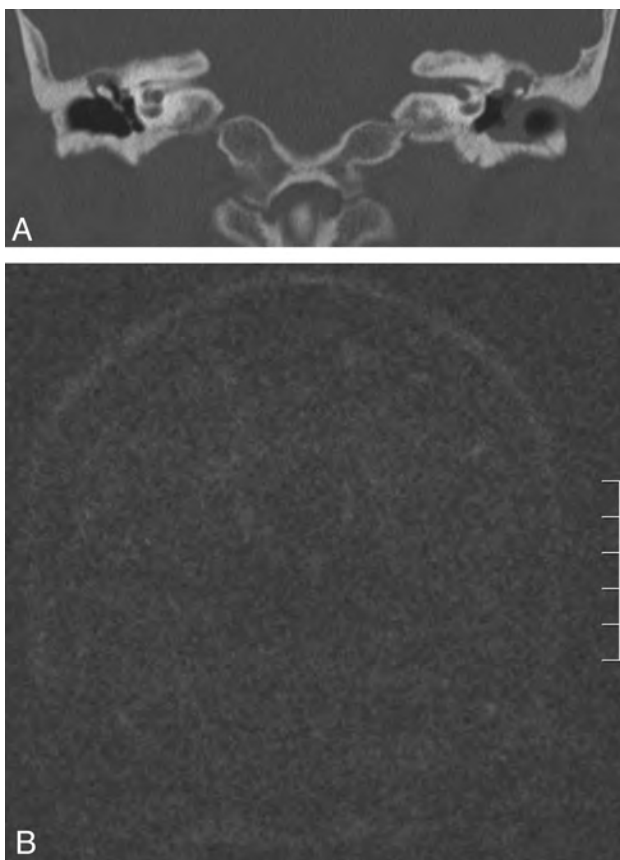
Case 13. A 58-year-old woman with bilateral chronic ear disease (right tympanic retraction pocket and left external ear canal stenosis). A, Coronal CT shows a right-sided tympanic retraction pocket with partial thickening of the tympanic membrane and erosion of the scutum, with an epitympanic middle ear mass. On the left side, there is external ear canal occupation by a soft-tissue attenuation mass, with epitympanic opacity. B, Coronal HASTE image negative for cholesteatoma. Surgery confirmed the presence of a retraction pocket without invasion of skin into the middle ear on the right side (not shown).
